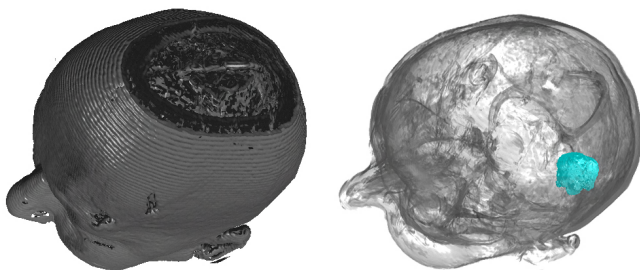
Volume rendering of the MRI data. The image on the left shows the shaded outer surface, which has been rendered semi-transparent in the image on the right to make the segmented tumor visible
